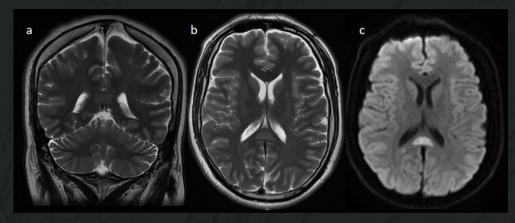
29-year-old man hospitalized for COVID pneumonia and suspected encephalitis on coronal and axial T2-weight image (a, b) and axial DWI (c) on 1,5T MRI. Diffusion restriction (c) in the splenium of the corpus callosum and T2 hyperintensity (a, b) suggestive of cytotoxic injury compatible with cytotoxic lesions of the corpus callosum (CLOCCs) associated with SARSCoV2 infection.
